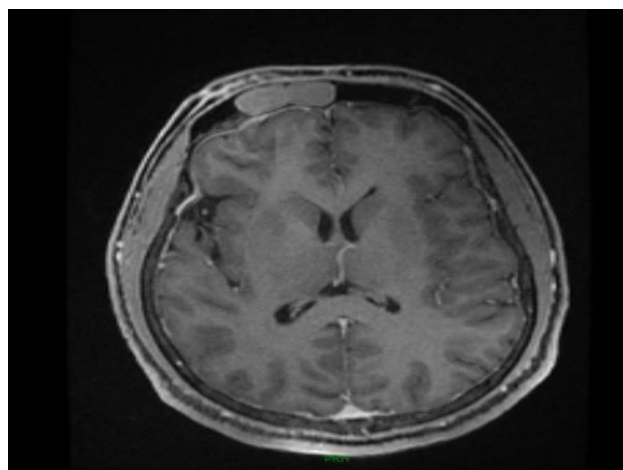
MRI brain (axial view) of extension of the tumor up to the frontal lobe.
